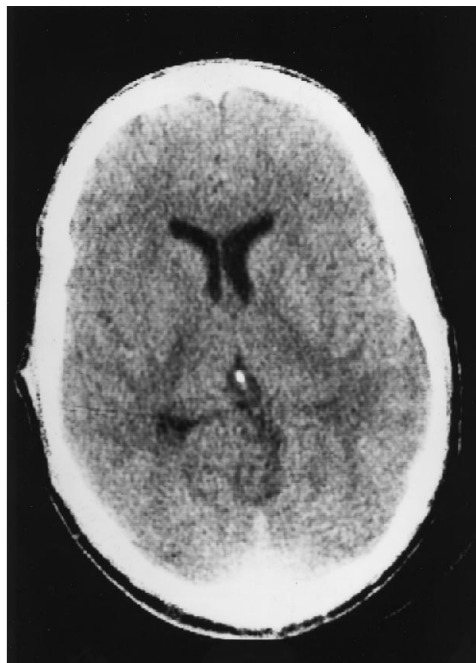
CT scan 1 day after ingestion of methanol does not show putaminal or white matter lesions.
